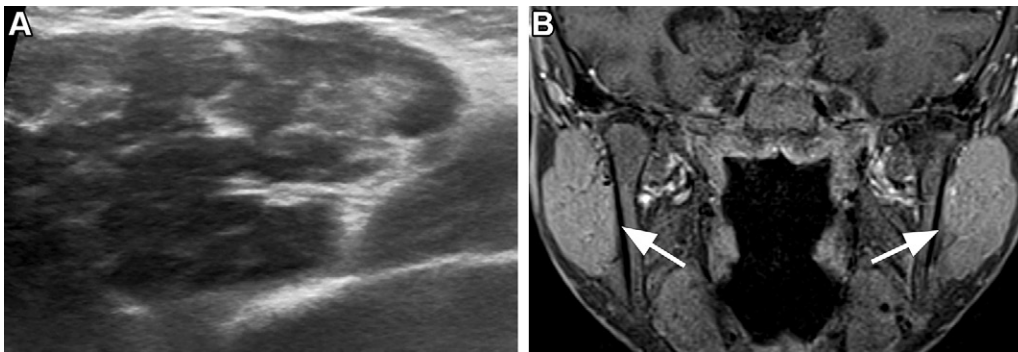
Bilateral parotid involvement in a 12-year-old boy with sarcoidosis. (A) US image shows right parotid gland enlargement and diffuse parenchymal heterogeneous hypoechogenicity. (B) Coronal postcontrast T1-weighted MR image shows bilateral parotid gland enlargement (arrows) without a focal lesion.
